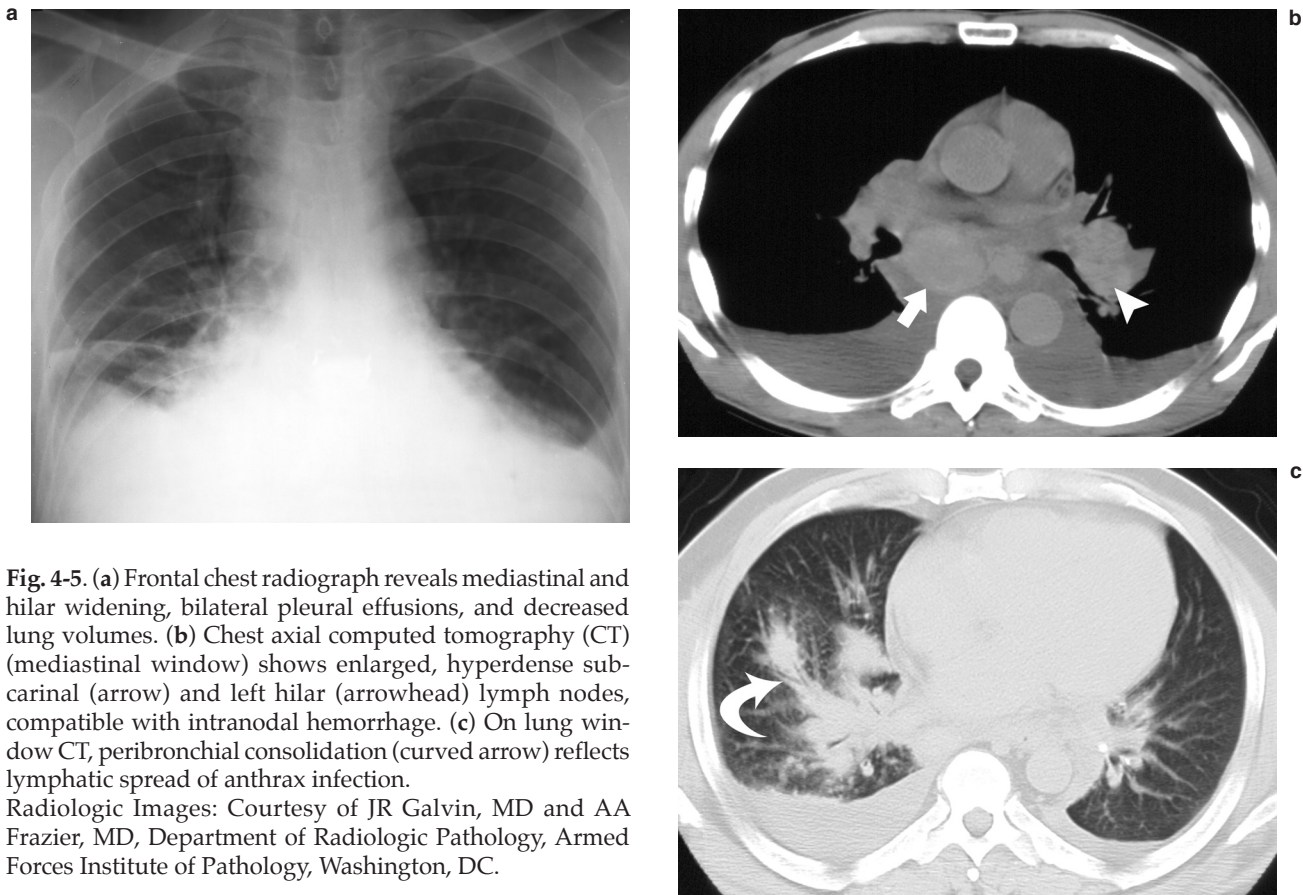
(a) Frontal chest radiograph reveals mediastinal and hilar widening, bilateral pleural effusions, and decreased lung volumes. (b) Chest axial computed tomography (CT) (mediastinal window) shows enlarged, hyperdense subcarinal (arrow) and left hilar (arrowhead) lymph nodes, compatible with intranodal hemorrhage. (c) On lung window CT, peribronchovascular consolidation (curved arrow) reflects lymphatic spread of anthrax infection.
